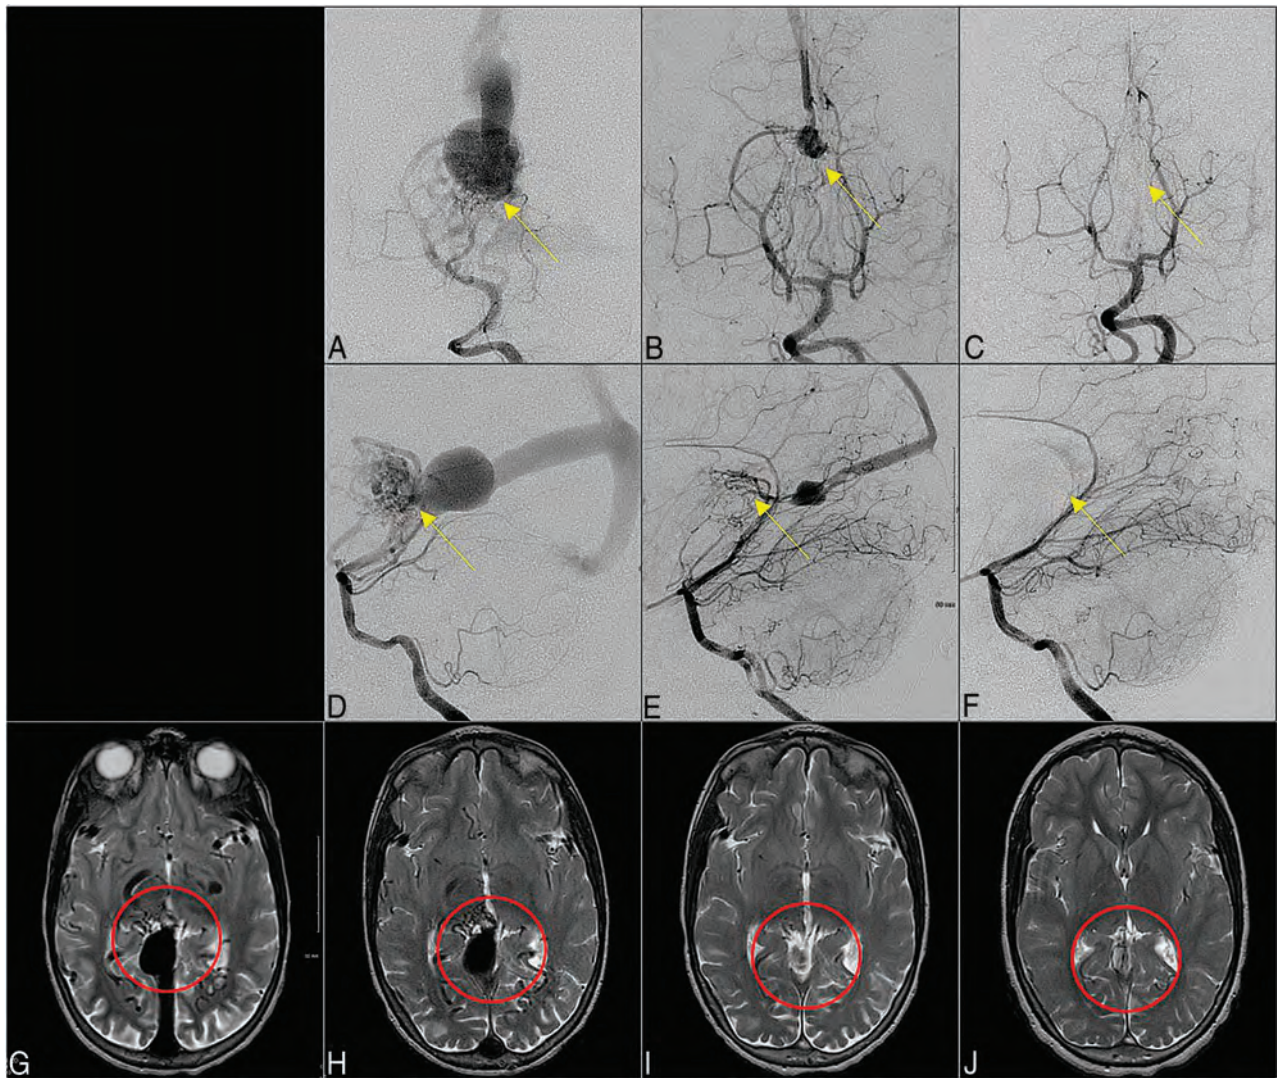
Angiogram. Anterior-posterior (A–C) and lateral (D–F) views of the angiogram and T2-weighted MR imaging (G–J) of case 22. We show an up-regulation (H) and waning (B and C, E and F, I and J) of a plexiform network centered around the right hypothalamus and quadrigeminal cistern. The FVNF observed at 4 months post-initial consultation was rectified with staged embolization and obliterated by the 6-year follow-up (C, F, J).
